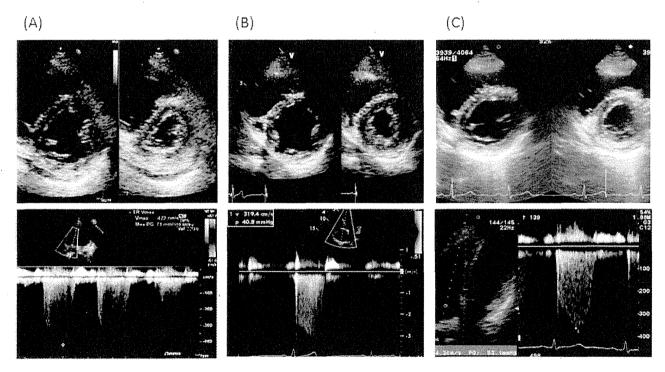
Improvement in transthoracic echocardiogram of responder 2. Upper panels are parasternal short-axis view images in diastole and end-systole, and lower panels are tricuspid regurgitation (TR) velocity images. A) Before administration of amlodipine in October 2009, septal flattening at end-systole was observed (upper panel). TR velocity was 422 cm/s (lower panel) and TR pressure gradient (TRPG), which is used for estimation of systolic PAP, was 71 mmHg. B) At six days after starting administration of amlodipine at 2.5 mg in November 2009, septal flattening at end-systole was improved (upper panel). TR velocity was 319.4 cm/s (lower panel) and TRPG was 41 mmHg. C) With administration of amlodipine at 5 mg in January 2011, septal flattening at end-systole was improved (upper panel). TR velocity was 364.3 cm/s (lower panel) and TRPG was 53 mmHg.
